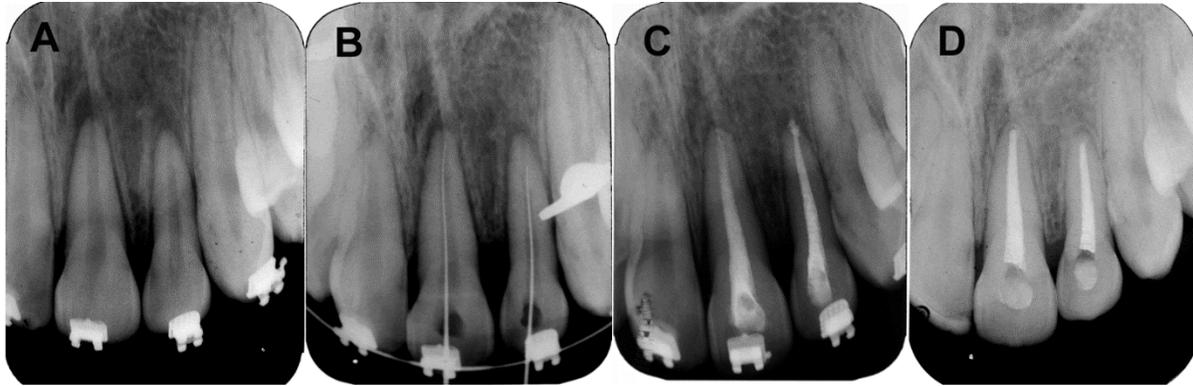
Radiographic images; *A*) Preoperative periapical radiography of the tooth #21 and tooth #22 showing the integrity of root surface and increased periodontal ligament space; *B*) Periapical radiography of odontometry during root canal treatment; *C*) Periapical radiography with root canals instrumented and filled with calcium hydroxide paste; *D*) Periapical radiography of the 5-year control showing the integrity of root surface and periodontium
